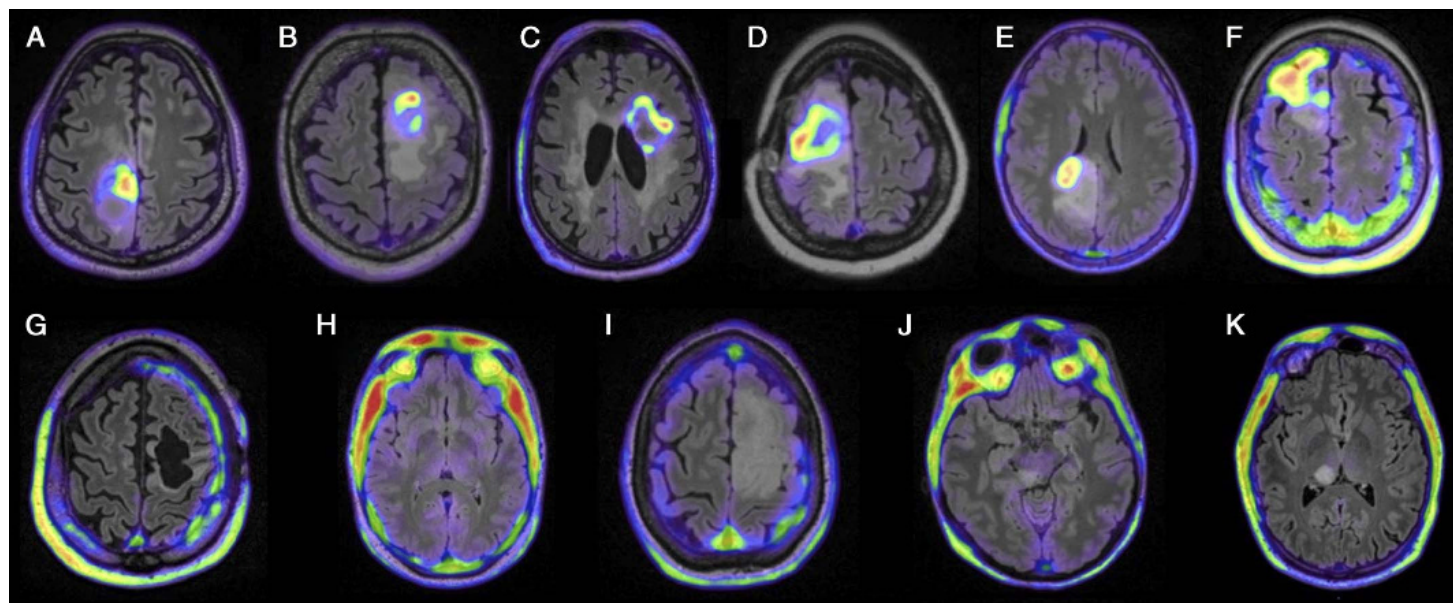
Fused PET/FLAIR images of all patients ordered from highest to lowest TBR. Patients with PET-positive tumors in top row: (A) patient 2, (B) patient 7, (C) patient 4, (D) patient 10, (E) patient 11, and (F) patient 1. Patients with PET-negative tumors in bottom row: (G) patient 3, (H) patient 6, (I) patient 8, (J) patient 9, and (K) patient 5. The PET color scale was set from SUV_{bg} to SUV_{max} for PET-positive tumors and from SUV_{bg} to $SUV = 2$ for PET-negative tumors, to better visualize the MRI scans.
